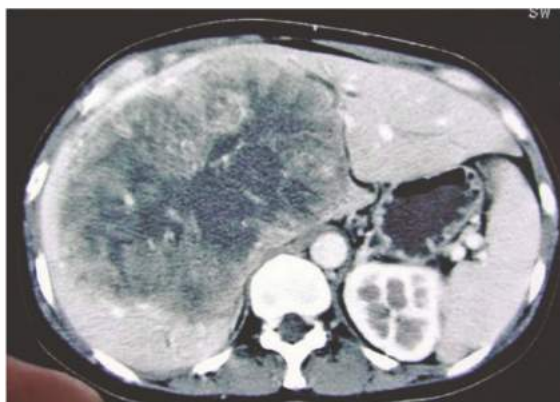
• Preoperative CT scan showing a very large liver tumor located at segments 4 to 8 with infiltration into the caudate lobe. The IVC is not clearly identified and invasion of the IVC versus compression cannot be determined. Surgical exploration revealed the IVC was not involved. A right trisegmentectomy was performed.
